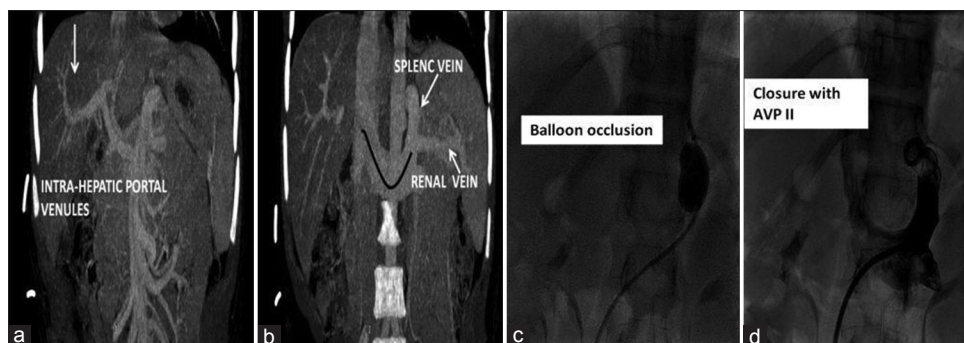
(a and b) Computed tomography abdomen coronal images showing distal splenic vein draining into left renal vein and then into inferior vena cava and also the presence of Intrahepatic portal venules is seen. (c) Showing balloon occlusion and measurement of portal pressure during the closure of malformation. (d) Shows complete closure of the shunt with no residual shunt across the device (amplatzer vascular plug II)
